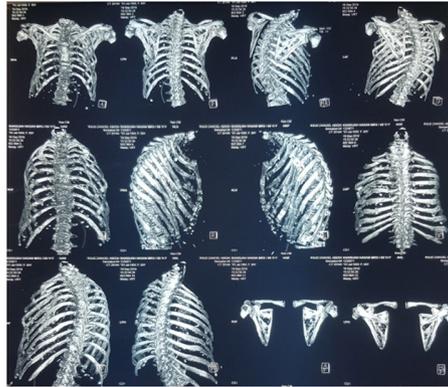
Thorax 3D CT-Scan showed multiple segmental ribs fracture
